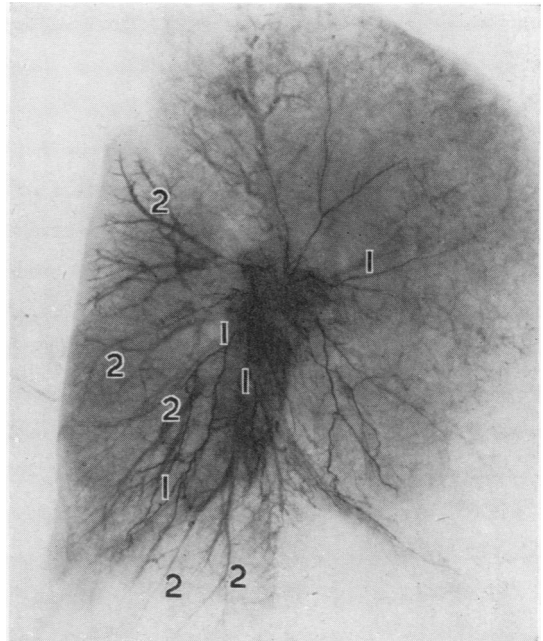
Case 14: lateral radiograph of left lung. The bronchial arteries (1) in the left lower lobe are tortuous and anastomose with the peripheral branches of the pulmonary arteries, which have also been outlined (2).
